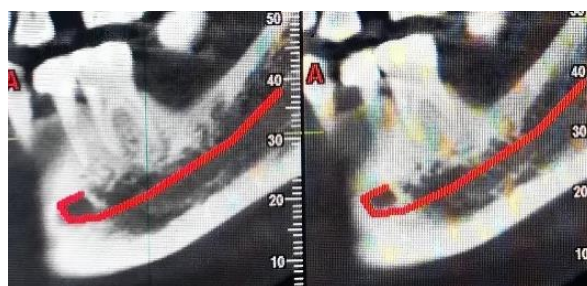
CBCT image shows anterior loop
